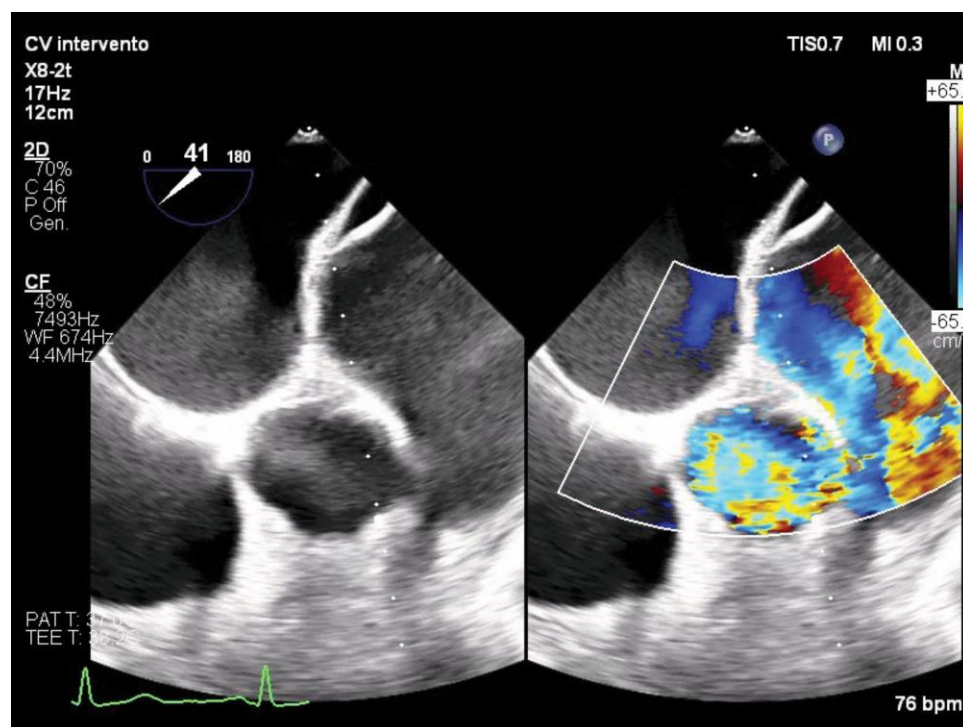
Intraoperative transoesophageal echocardiography in a mid-oesophageal short-axis view above the aortic valve plane. It shows abnormal flow between the aorta and the pulmonary trunk.
